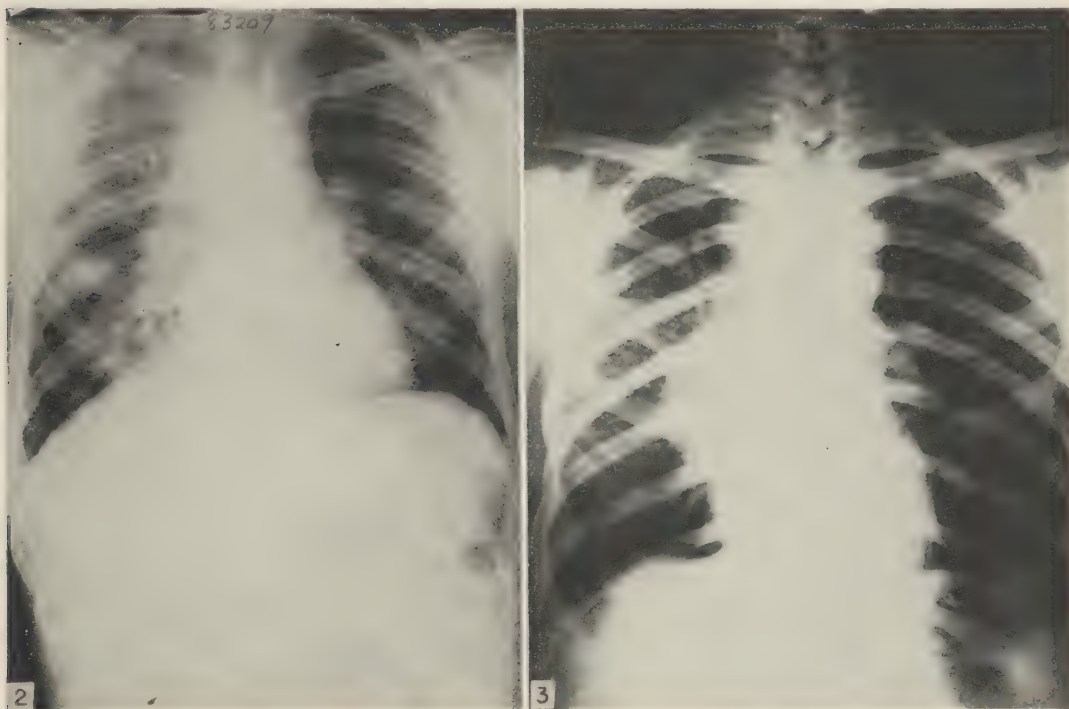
Primary pulmonary coccidioidomycosis, AIP Ac. 83209: Roentgenogram of unilateral diffuse confluent bronchopneumonia with cavity formation, accompanied by massive mediastinal lymphadenitis. Death on 60th day of the disease with widespread dissemination of lesions. Gross appearance of the lung was not unlike that shown in Figs. 7 and 8.
